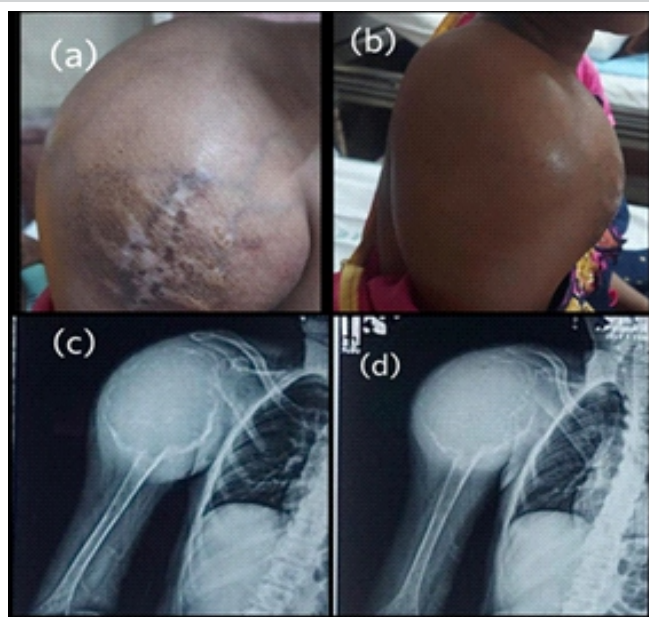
Pre-operative clinical photograph. (a) Anterior aspect (b) Lateral aspect pre-operative radiograph. (c) Anteroposterior view (d) Lateral view.
